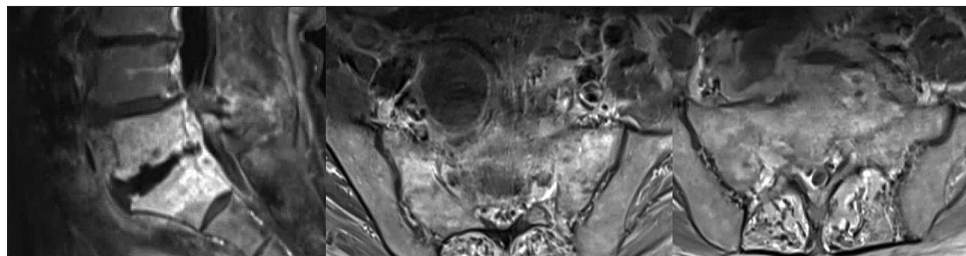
MRI at return in March 2018 – Increased height loss of L5 vertebral body with epidural phlegmon resulting in severe L5-S1 foraminal stenosis. An extensive prevertebral phlegmon is abutting the large right common iliac artery and graft.
